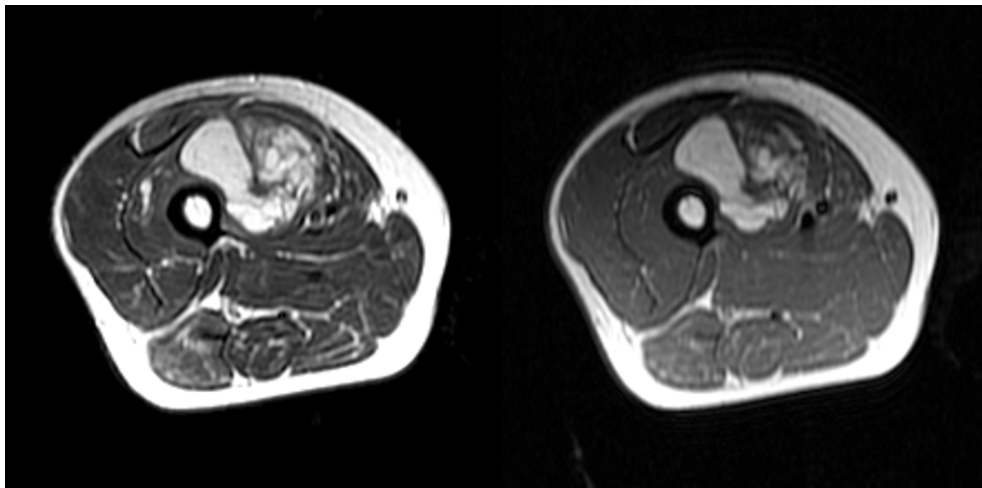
Magnetic resonance images of the right thigh before surgery. A: T1-weighted axial image. B: T2-weighted axial image. One part of the tumor showed high signal intensity in both T1- and T2-weighted images, suggestive of atypical lipomatous tumor, while the other part showed low and high signal intensity on T1- and T2-weighted images, suggestive of dedifferentiated liposarcoma.
